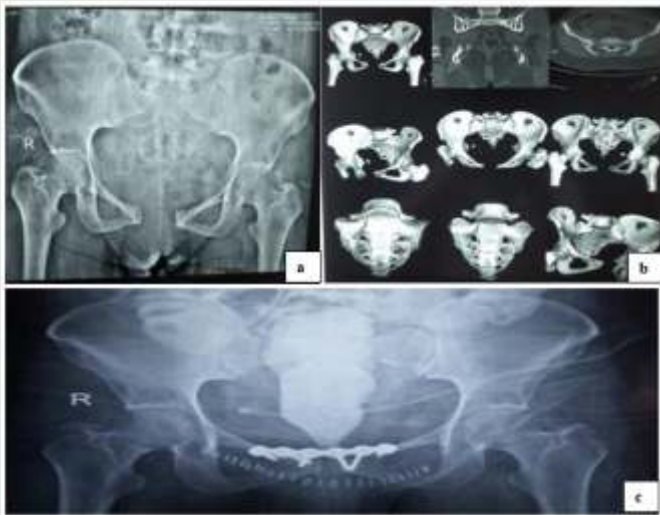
(a) Pre-operative X-ray, (b) pre-operative CT scan, and (c) post-operative X-ray.
